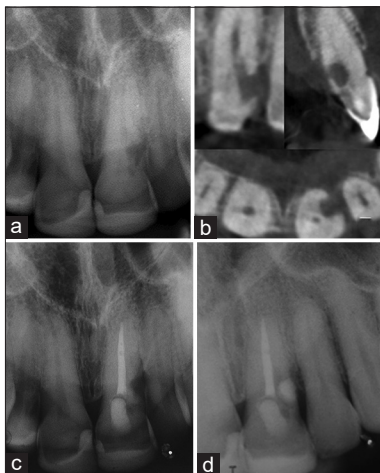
External cervical resorption of maxillary left central incisor. (a) Preoperative periapical radiography. (b) Cone beam computed tomography. (c) Endodontic treatment. (d) 18 months follow-up: Radiographic aspects
